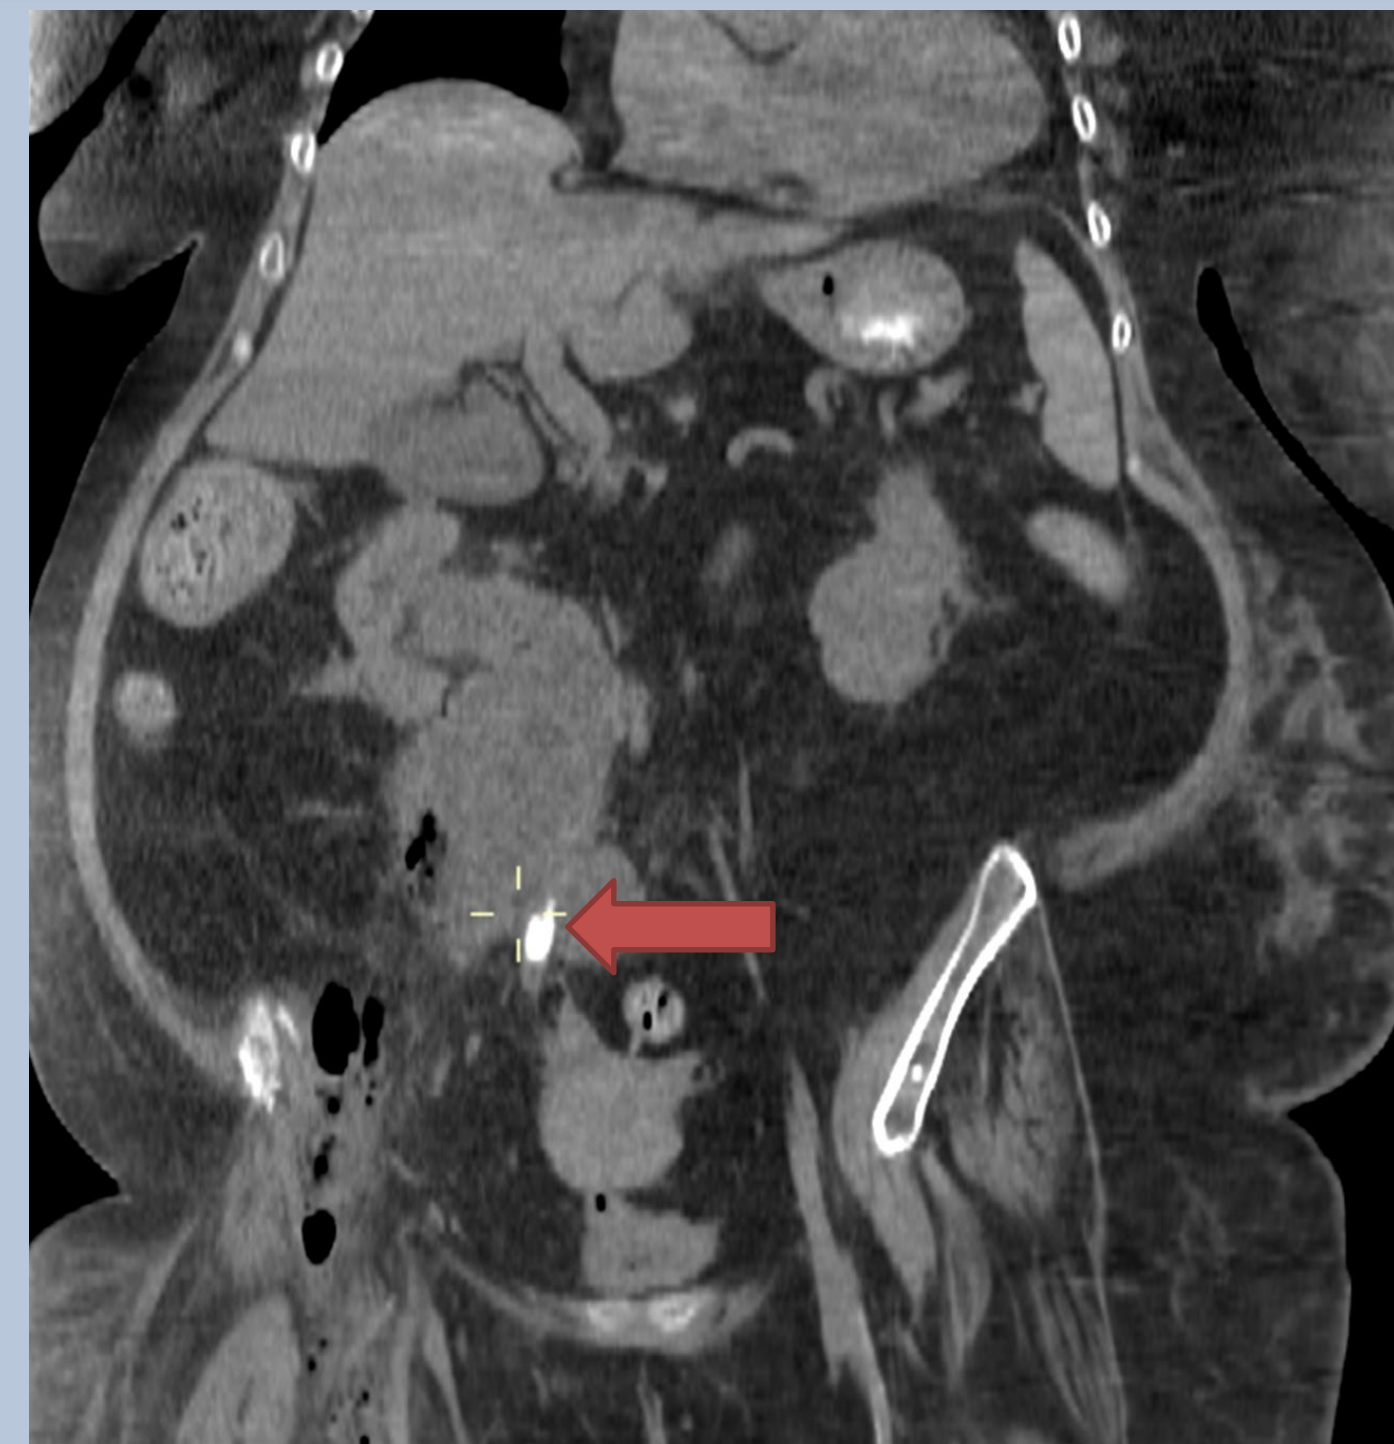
CT without contrast demonstrating perforated kidney stone (arrow) with surrounding abscess and air.
